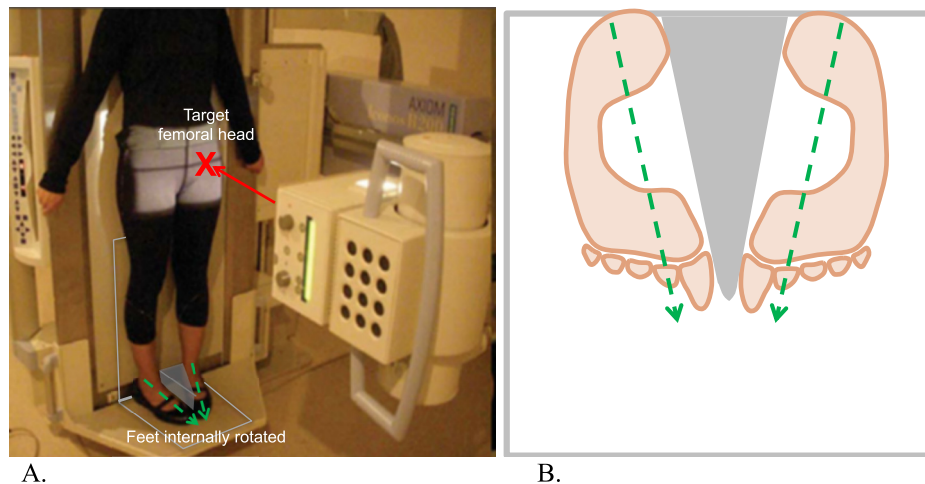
Standing AP view. Subject stands on Fixed Flexion Frame facing X-ray tube with the feet internally rotated along the V-shaped guide on the floor of the frame (B) and the heels touching the back wall of the frame. The X-ray beam is centered on the index hip (A).
